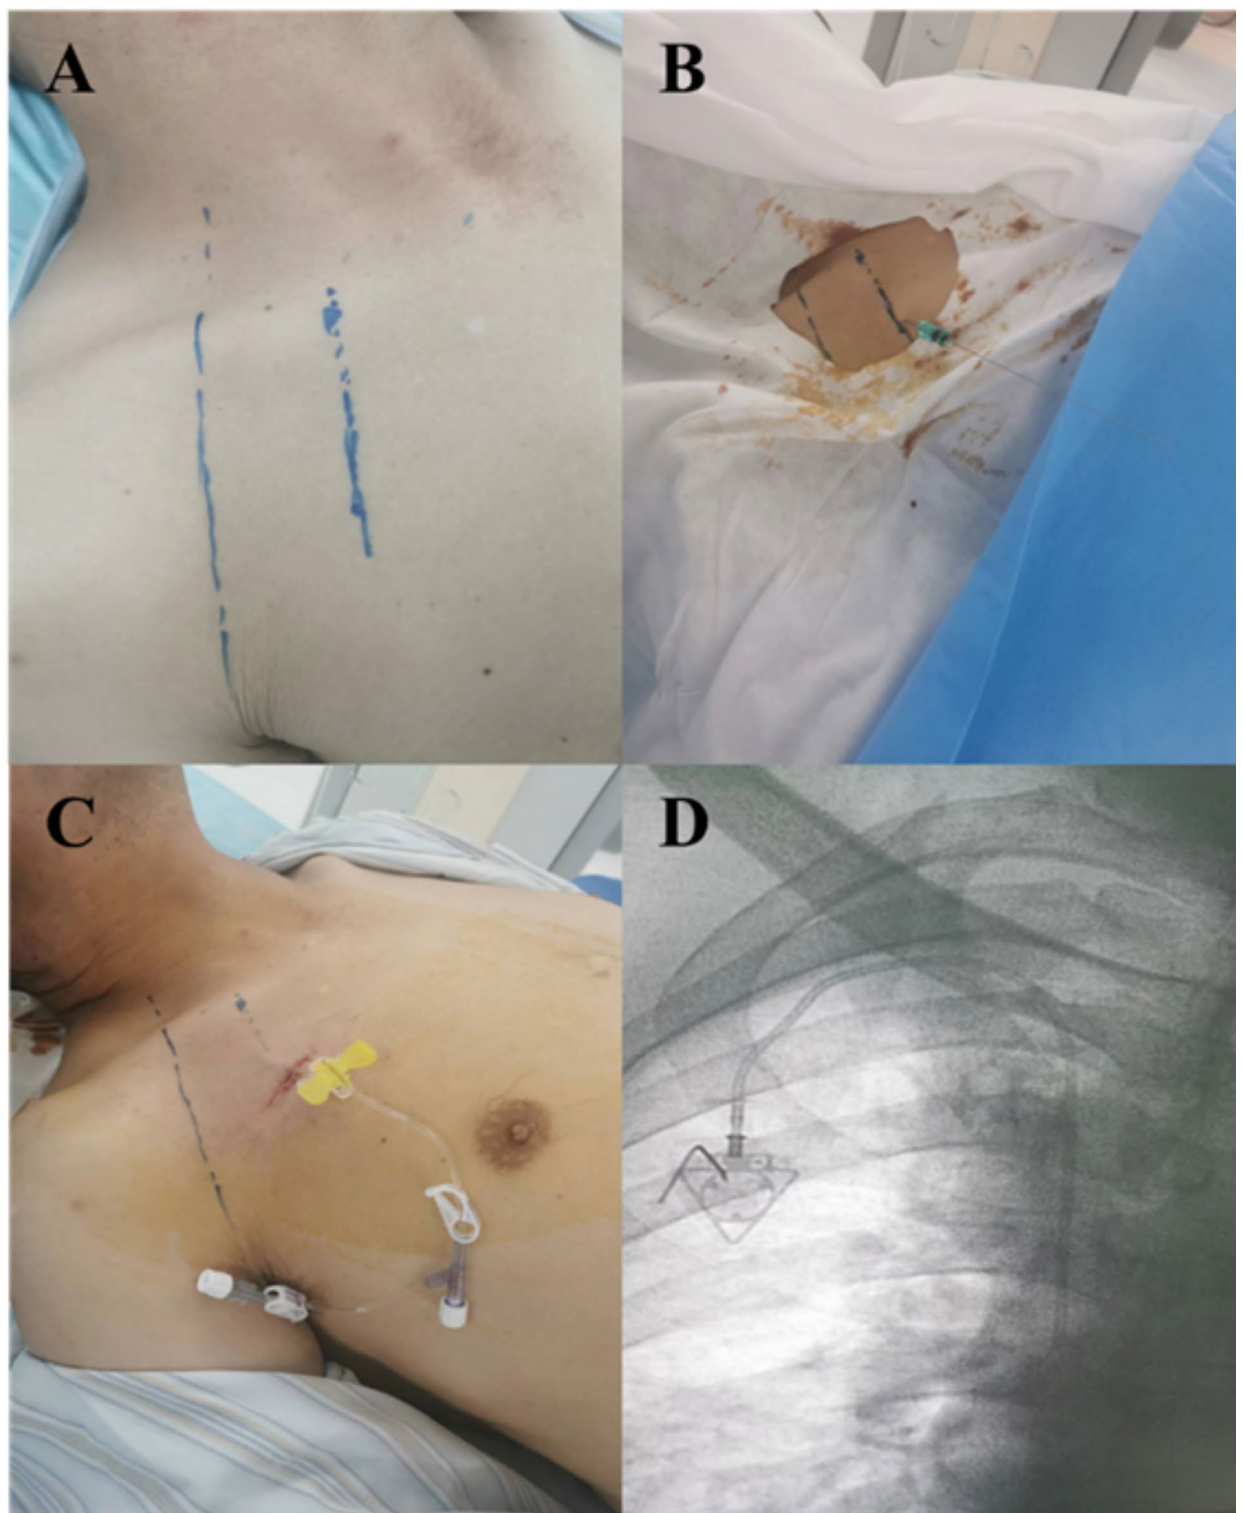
Sequential stages of axillary vein puncture for TIVAPs placement. (A) Anatomical landmarks for axillary vein puncture. (B) Guidewire insertion into the axillary vein. (C) Full subcutaneous implantation of the TIVAPs. (D) X-ray visualization of the TIVAPs.
